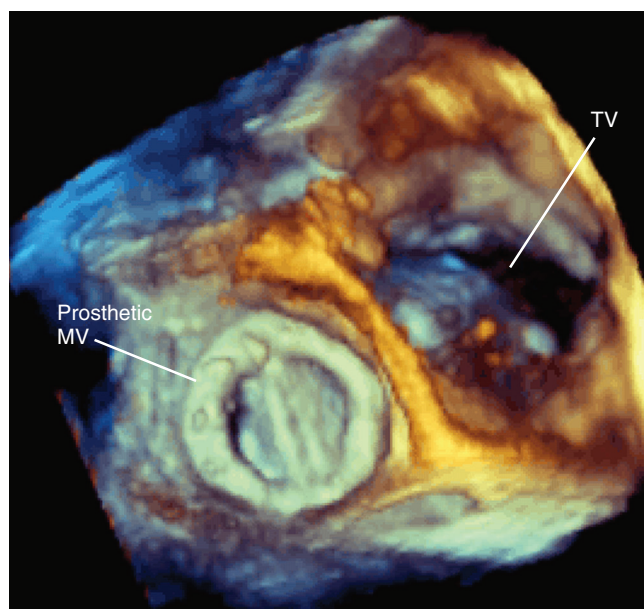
■ Three-dimensional echocardiographic imaging of a prosthetic mitral valve (MV) seen from the atria. TV, Tricuspid valve.
